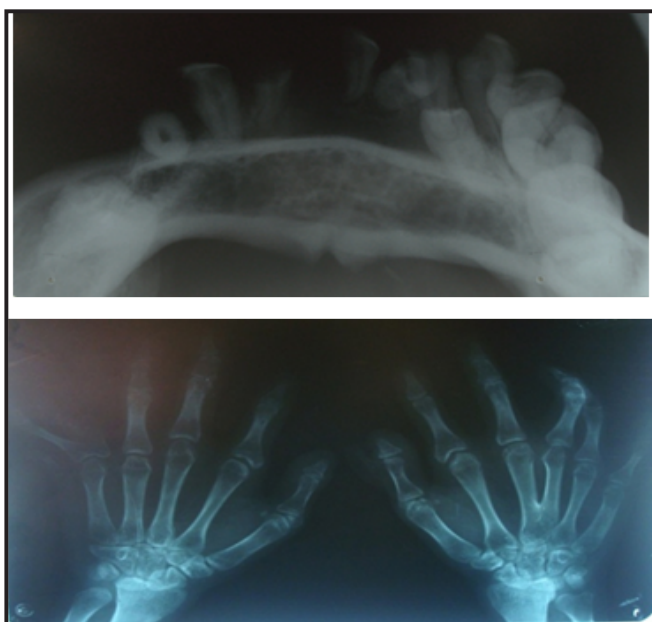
Hypoplasia of mandible and partial anodontia, radiograph of feet showed polydactyly and bilateral reduplicated hallux.
